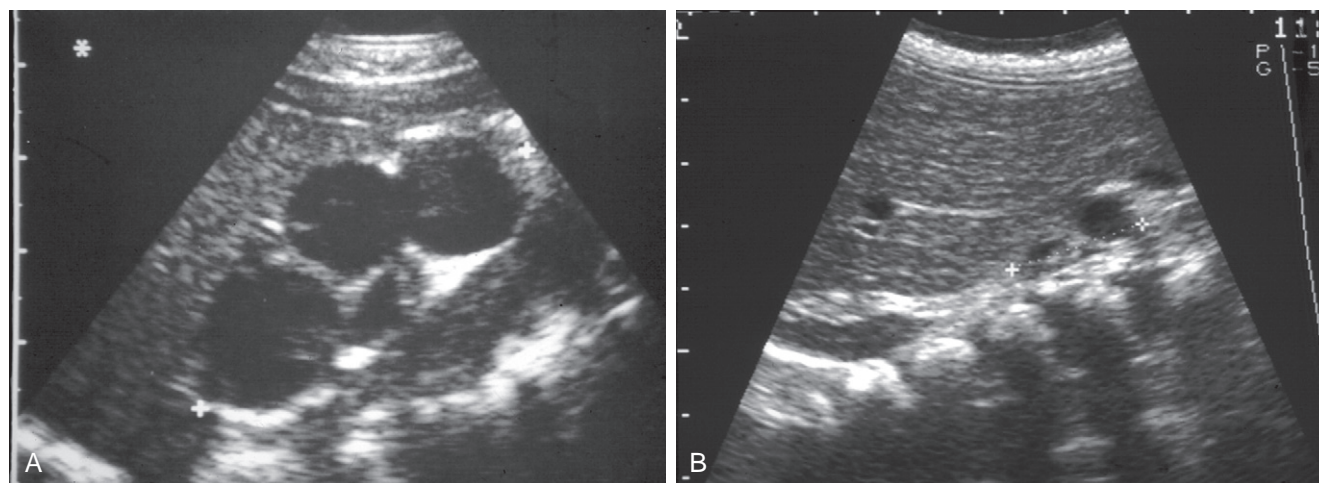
A, Multicystic kidney identified on ultrasonography in a newborn. B, At age 9 months, the cysts have shrunk, and the kidney is barely visible. (From Shah SM, Glassberg KI: Multicystic dysplastic kidney disease. In Gearhart JP, Rink RC, Moriquand PDE [eds]: *Pediatric Urology*. Philadelphia, WB Saunders, 2001, p 284.)
